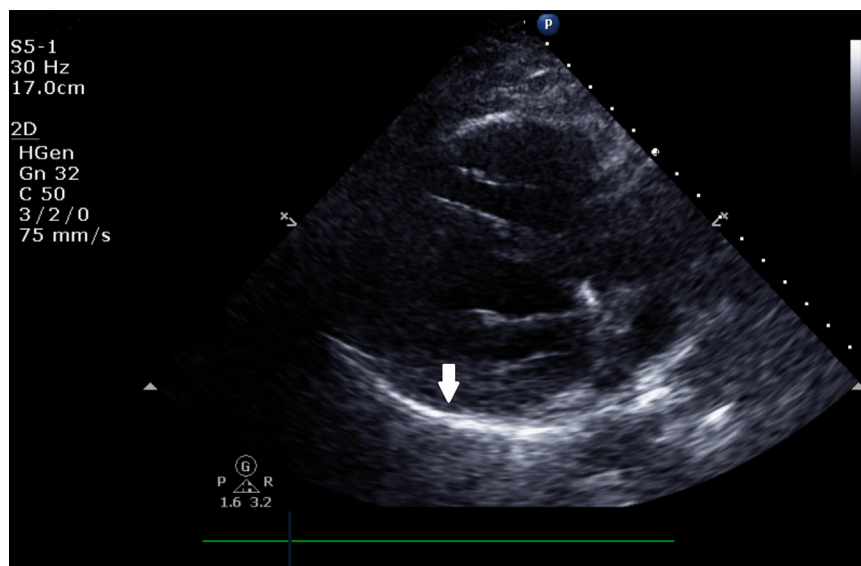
Transthoracic echocardiogram after pericardiocentesis and drain placement. White arrow shows now resolved pericardial effusion.
